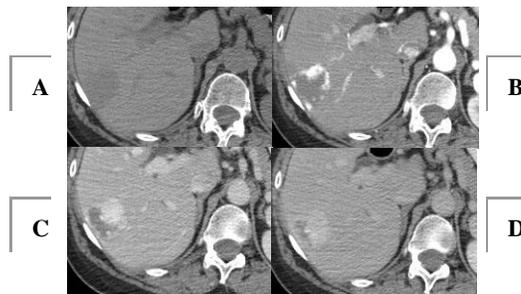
Hemangioma. A: On unenhanced CT it is hypodense; B: On arterial phase it has nodular peripheral enhancement; C: Portal venous phase demonstrating centripetal enhancement of the lesion; D: Delayed imaging showing almost full fill in of the lesion with contrast. Note that on all phases of imaging the regions of enhancement are as dense as the aorta.
